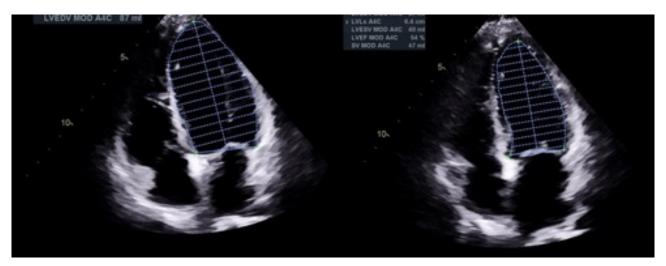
Follow-up transthoracic echocardiogram showing left ventricular ejection fraction of 54% using the biplane Simpson method with normal left ventricular size.
